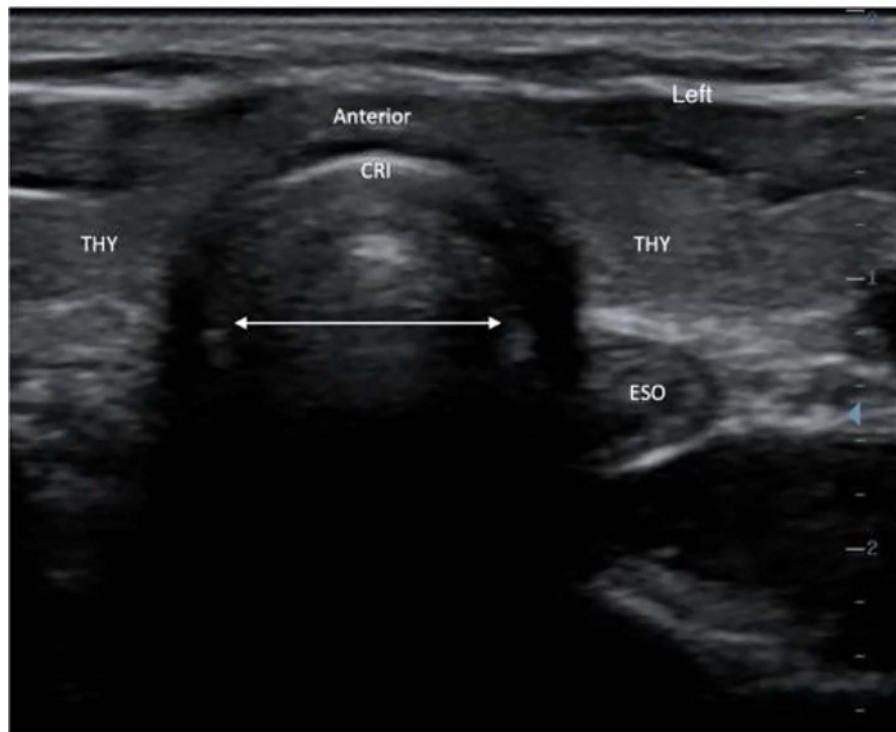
Ultrasound image of the airway using a linear probe showing the anatomy of the subglottic region. The arrows indicate the diameter of the subglottic area, which can be used to estimate the external diameter of the appropriate tube size. CRI, cricoid cartilage; THY, thyroid; ESO, oesophagus (figure courtesy of Vinicius Quintao).
